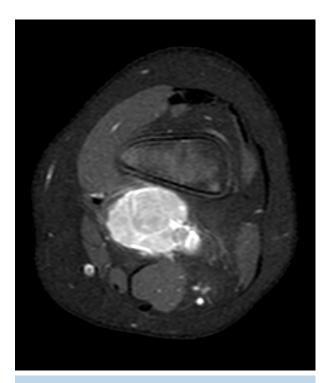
Heterogenous and lobulated mass seen within the popliteal fossa on initial MRI.
